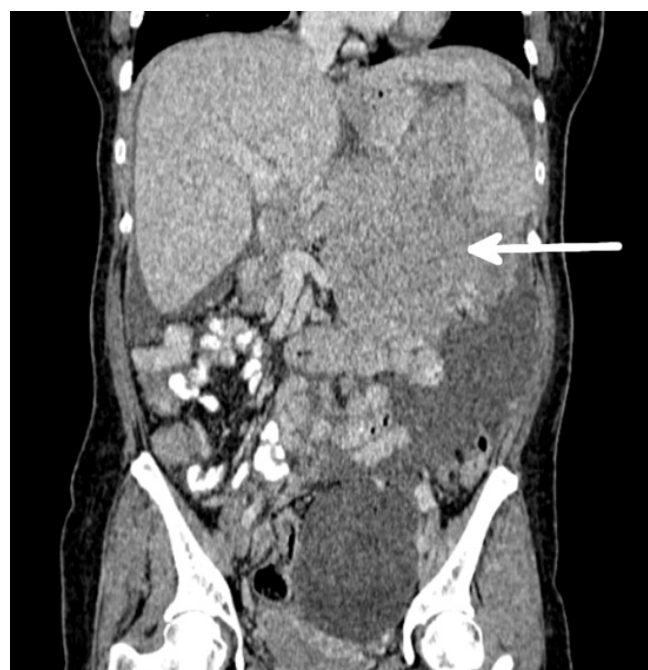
Coronal view of contrast-enhanced computed tomography of pancreatic protocol; the white arrow represents the location of the tumor on the scan.
